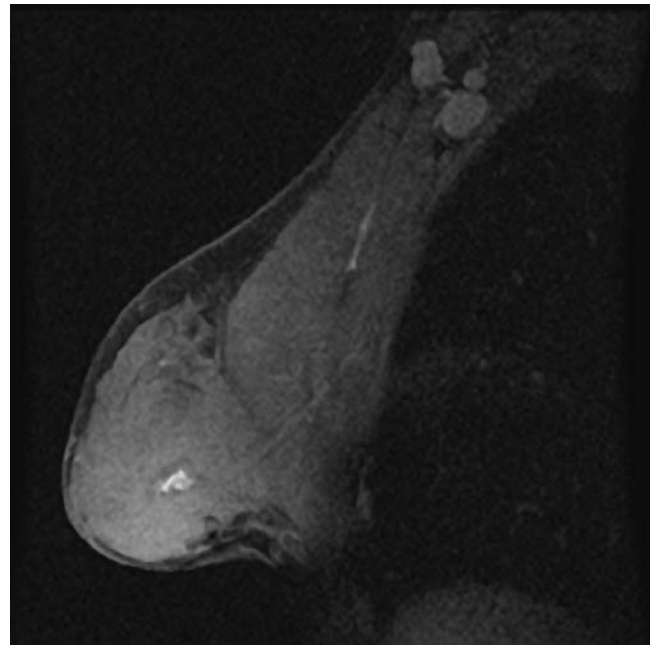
Unilateral sagittal image through the lesion shown in the left breast of the bilateral image in Figure 2.1. The higher spatial resolution demonstrates the well-circumscribed nature of the lesion and the internal dark septations that are characteristic of fibroadenomas. (Reproduced with permission from American College of Radiology (ACR). ACR BI-RADS®–Magnetic Resonance Imaging. In: *ACR Breast Imaging Reporting and Data System, Breast Imaging Atlas*. Reston, VA. American College of Radiology; 2003.)
